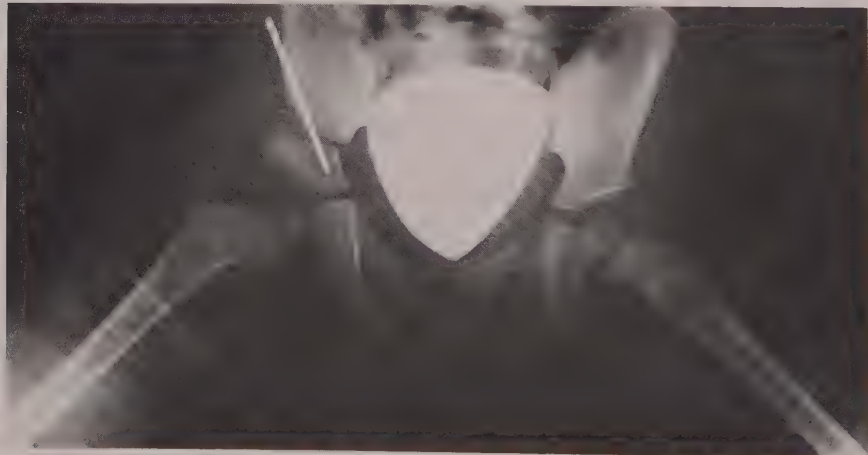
The same patient as Fig. 47.1 after operative reduction and stabilisation by osteotomy of the pelvis immediately above the acetabular roof. The osteotomy is held open by a wedge of bone fixed by a Kirschner wire. A gonad shield is in place to protect the ovaries from irradiation during the X-ray.
